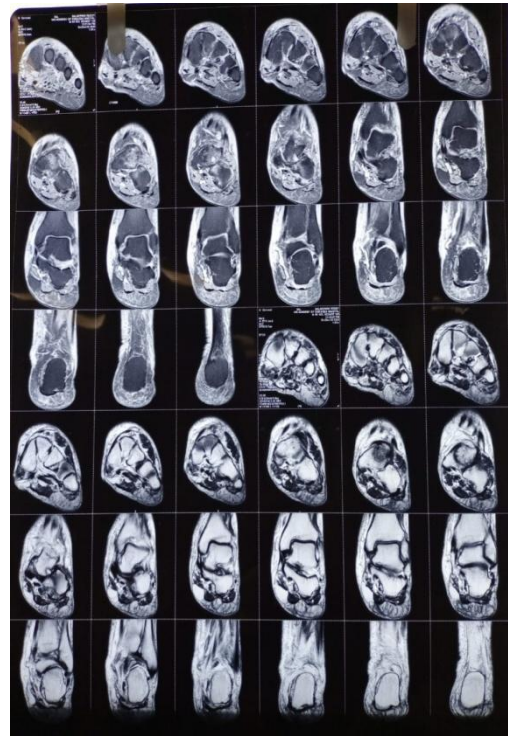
MRI scan of foot
